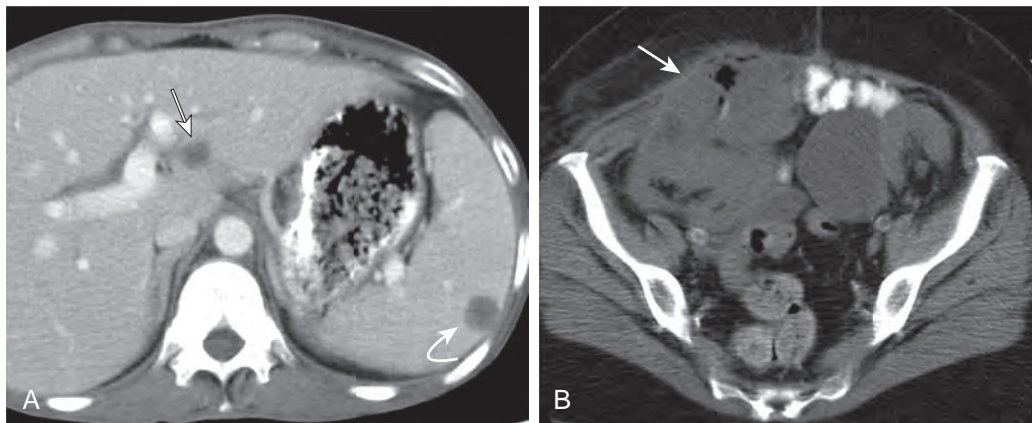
PTLD in two pancreas transplant recipients. A. Contrast-enhanced CT demonstrates rounded hypodense lesions in the liver (arrow) and spleen (curved arrow). B. Unenhanced CT in a different patient demonstrates a large necrotic mass arising from the small bowel and growing into the anterior abdominal wall (arrow). The pancreas transplant is not shown. Note bilateral renal transplants. (From Vandermeer F, Manning MA, Frazier A, et al: *Imaging of whole-organ pancreas transplants*. *RadioGraphics* 32:411–435, 2012.)
